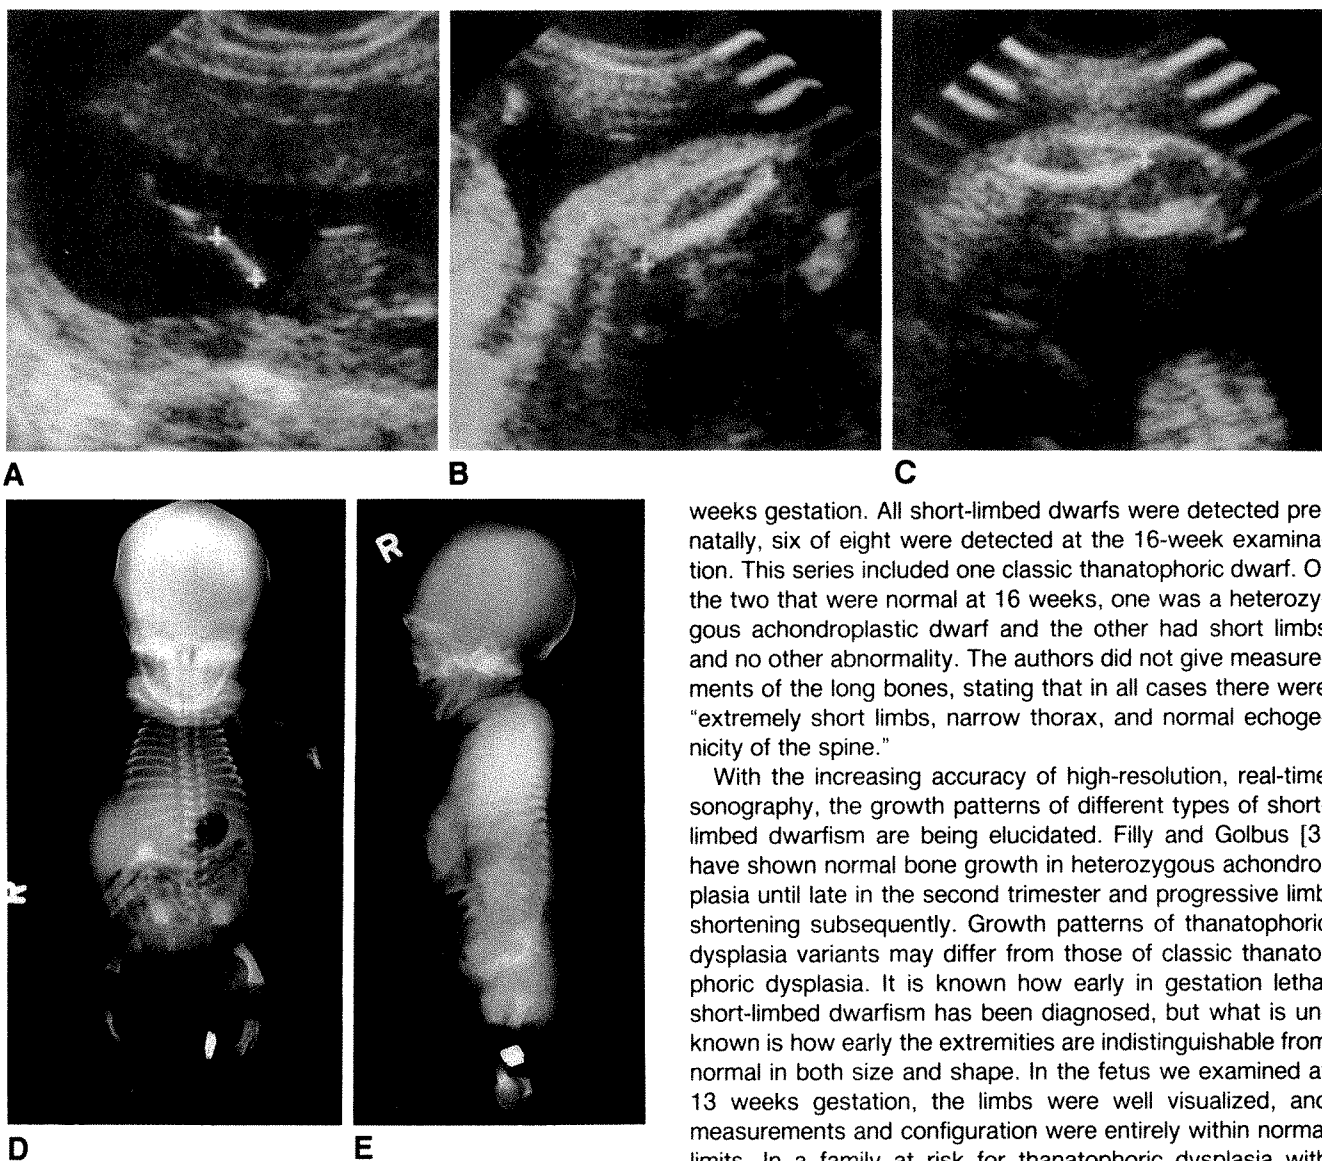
A, Sonogram of leg of fetus at 13 weeks shows absence of bowing and normal proportion of femur to lower leg.
